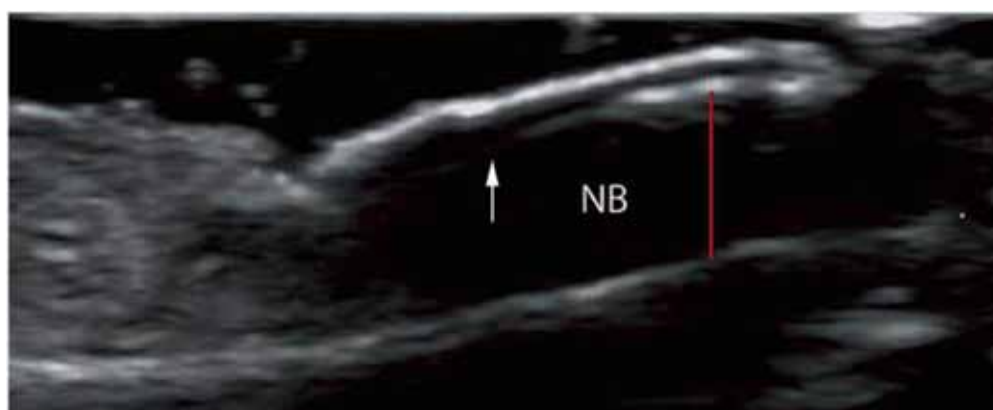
Sonography of psoriatic nail. © X. Wortsman, Chile
